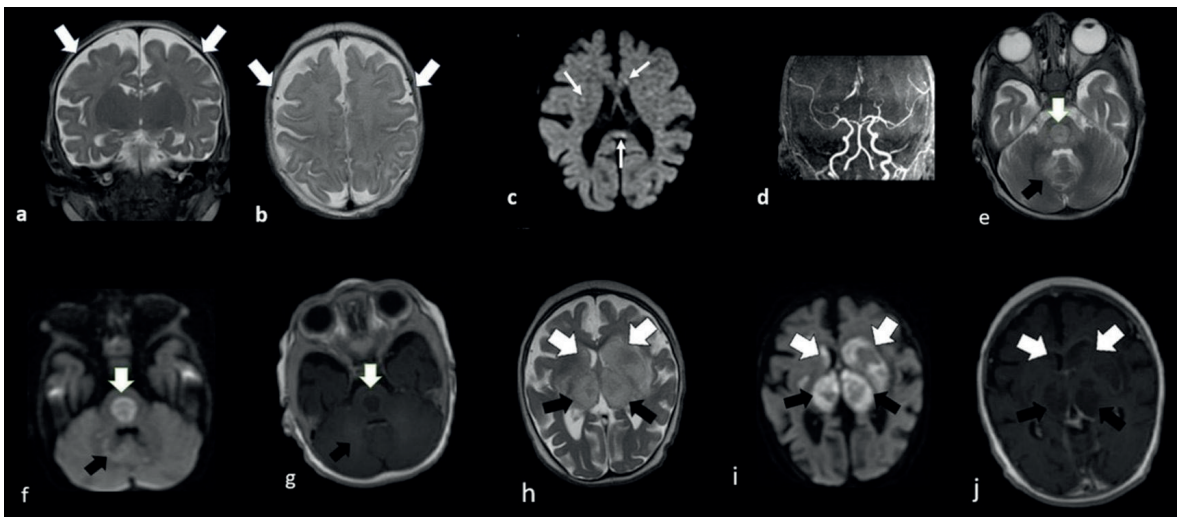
a, b. Brain magnetic resonance imaging (MRI) coronal (a) and axial (b) T2-weighted (T2W) sequence. The gyral pattern appeared shallow for the patient's age and may be associated with prematurity (white arrows). c. Diffusion-weighted image (DWI) revealed punctate restricted diffusion values in the posterior and midline of the splenium of the corpus callosum, as well as in the subependymal areas adjacent to the lateral ventricle (white arrows). d. MR angiography was performed, which yielded normal results. e-g. Axial T2W (e), DWI (f) and post-contrast T1-weighted (T1W) images (g) show hyperintense edema with diffusion restriction, hemosiderin deposits, and peripheral enhancement in pons (white arrows) and dentate nucleus (black arrows). h-j. Axial T2W (h), DWI (i), and post-contrast T1W (j) images demonstrate hyperintense edema with diffusion restriction, hemosiderin deposition, and peripheral enhancement in both thalami (black arrows), and bilateral basal ganglia (white arrows).
